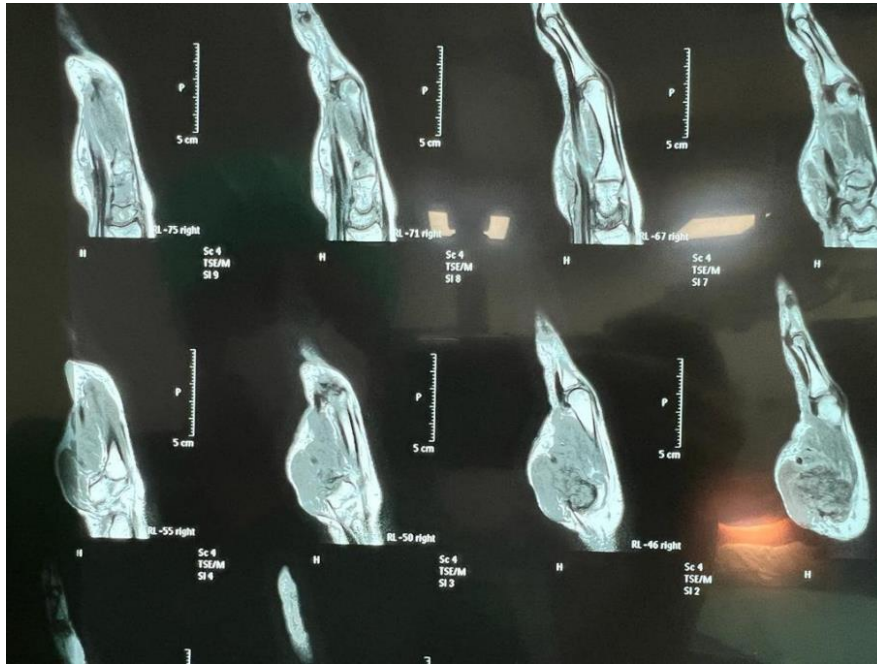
MRI examination showed low-intermediate T1 signal/ T2 high signal intracortical foci, separated by low T1/T2 signal cortical bone and sclerotic reaction with the prominent enhancement of the entire first metacarpal.
